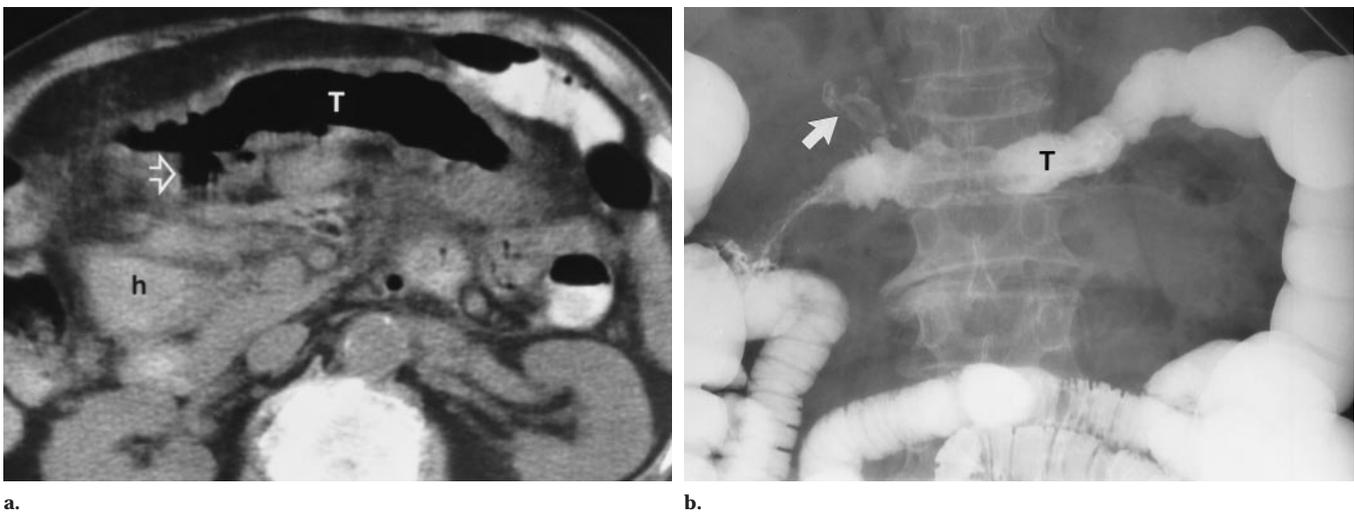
Ischemia of transverse colon in an 81-year-old man with arteriosclerosis, a recent syncopal episode, abdominal tenderness, fever, an elevated WBC count, and a decrease in the hematocrit. (a) CT scan obtained without intravenous contrast material shows high-attenuation fluid consistent with abdominal hemorrhage (*h*) that is associated with an ahastral transverse colon (*T*) with a thickened wall. Small collection of air (arrow) was present adjacent to the proximal transverse colon. (b) Radiograph obtained after administration of diatrizoate meglumine (Hypaque Meglumine; Sterling Winthrop, New York, NY) enema shows narrowing of transverse colon (*T*) with small extravasation (arrow) consistent with sealed-off perforation. Findings obtained at surgery performed 3 weeks after the initial episode confirmed these findings.
